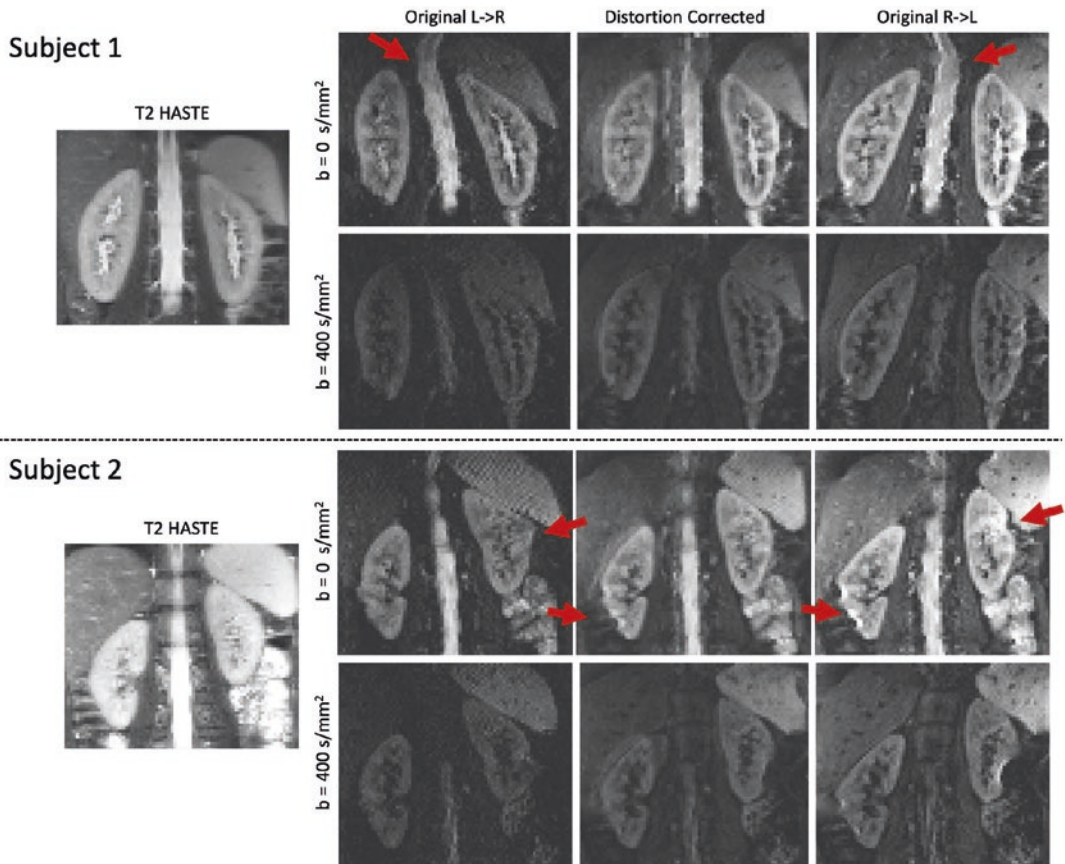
The comparison of the reference T_2 -HASTE image of two subjects and DW-MR images (for two b -values) before and after distortion correction for two representative subjects. The T_2 -HASTE reference (left column), original L- > R image (middle left), original R- > L image (right), and distortion-corrected image (middle right) are shown. Red arrows indicate areas where
